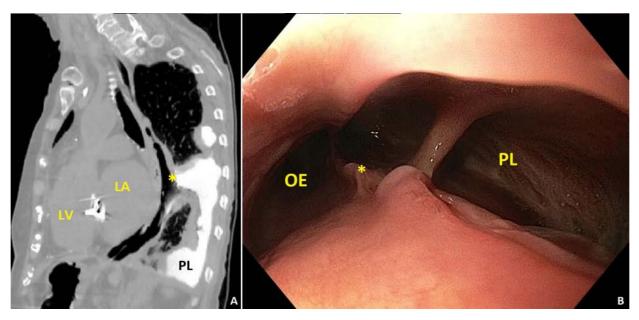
A: Computed tomography scan displayed pleural-esophageal fistula (indicated by the asterisk) with contrast effusion in the right pleura, the enlarged left atrium and its distortion of the oesophagus, at the level of the lesion. LA: Left Atrium; LV: Left Ventricle; PL: Right Pleura. B - Esophagoscopy showed the level and the extension of the fistula (indicated by the asterisk) on the right surface of the distal oesophagus, for the subsequent stenting procedure. OE: Oesophagus; PL: Right Pleura.
